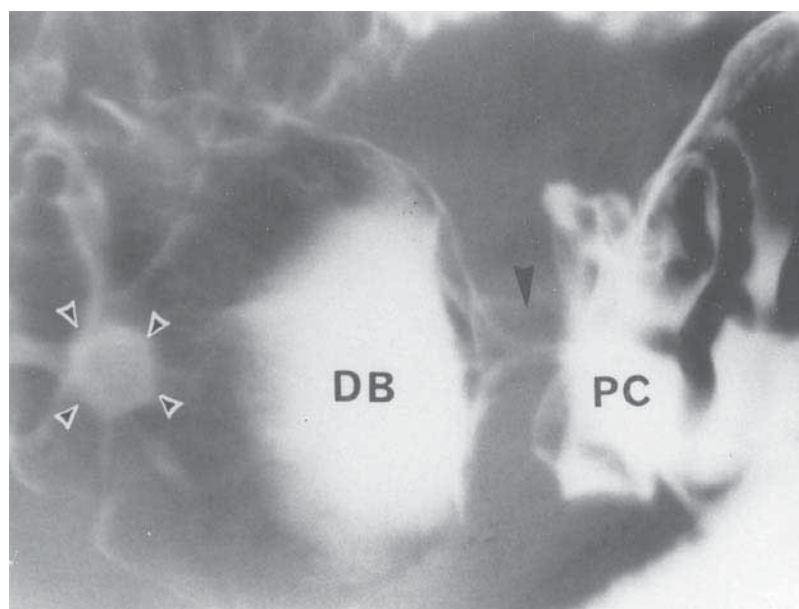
X-Ray of the Pyloroduodenal Junction Showing a Duodenal Ulcer
